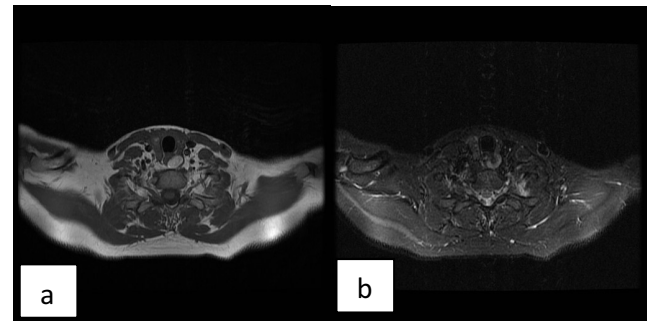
Retroesophageal dermoid cyst on T1-weighted axial scan (a) and fat-suppressed T2 axial scan (b).
